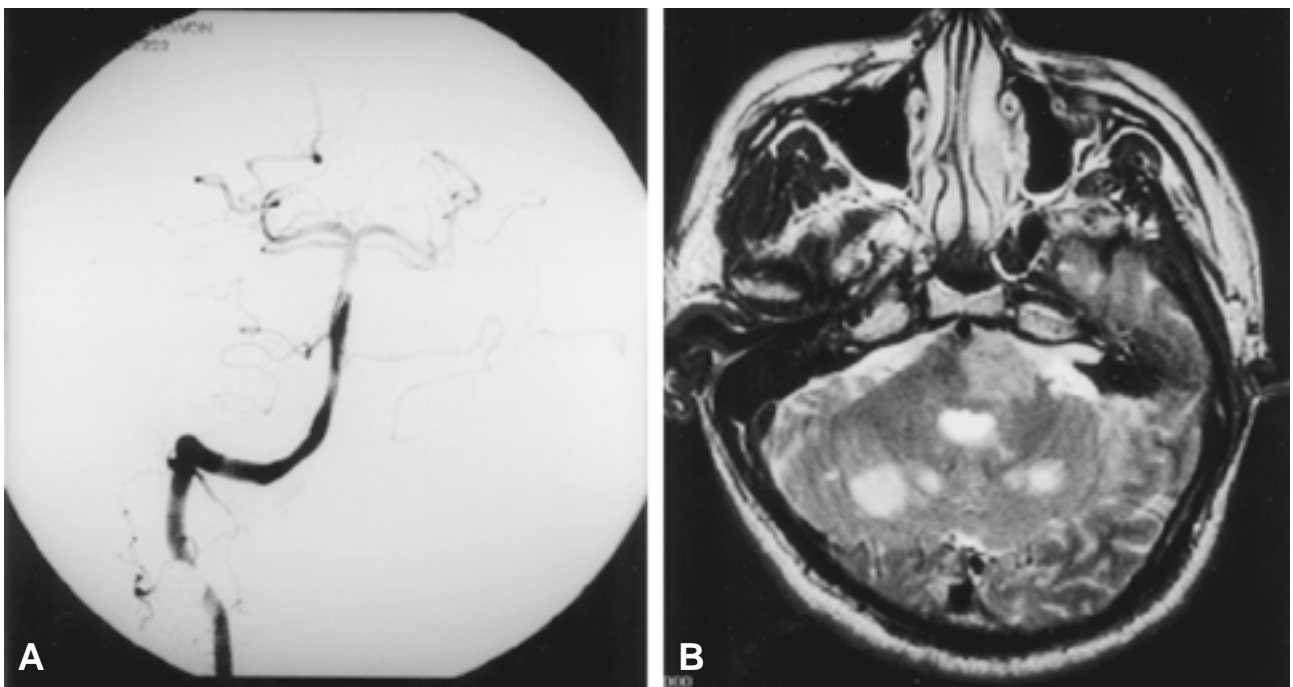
(A) Vertebral angiogram (anterior-posterior view) demonstrates an intimal flap originating from the anterior inferior cerebellar artery and luminal narrowing in the basilar artery. (B) Brain MR image (T2-weighted) shows acute infarction of the pons and both cerebellum due to multiple emboli.
